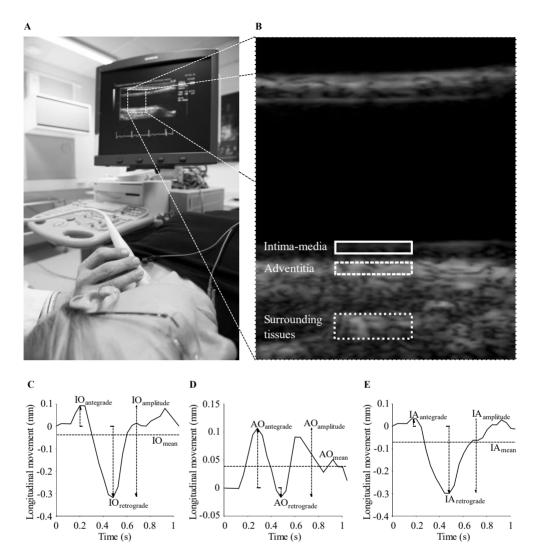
Measuring the longitudinal motion of the left common carotid artery (A) and the carotid artery wall longitudinal motion curves in the different arterial layers. B-mode ultrasound image of the common carotid artery and regions of interests (ROIs) are drawn on the carotid wall (B), where a solid line is drawn on the intima-media -complex, a dashed line on the adventitia layer and a dotted line on the surrounding tissue. In curves (C, D, E), the solid line represents the movement of the curve, and dashed lines refer to the maximum antegrade (ante), retrograde (retro) and peak-to-peak amplitudes (ampl).
